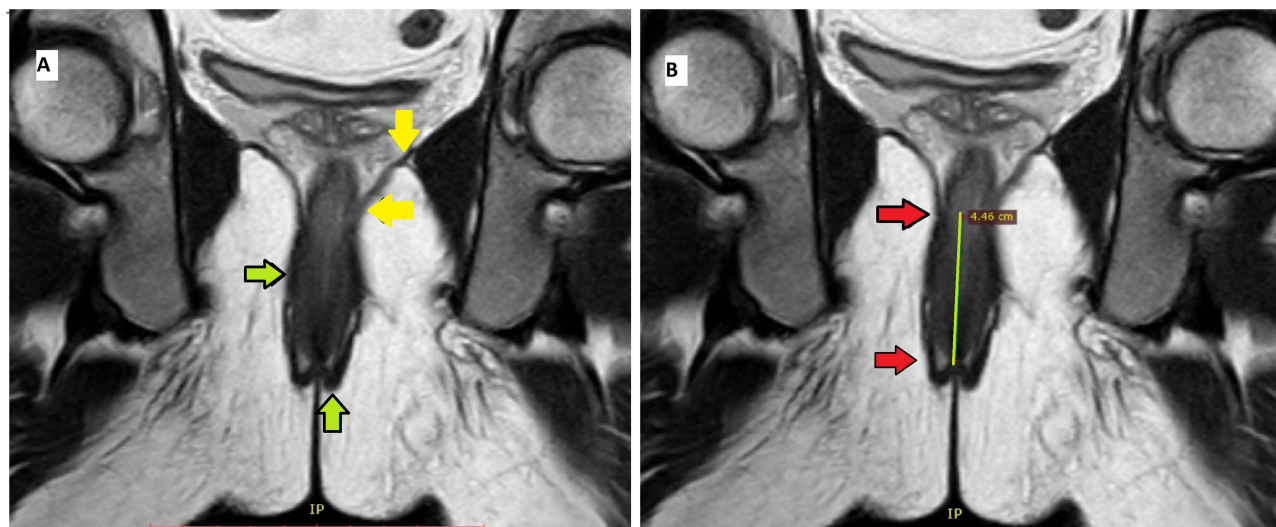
Normal anatomy- Coronal Section (MRI) and measurement of length of the surgical anal canal. Panel (A) (Left)- Green arrows showing the external anal sphincter. Vertical green arrow showing the lower border of the external anal sphincter (subcutaneous part). Horizontal green arrow showing the mid-part of the external anal sphincter (superficial part). Yellow arrows showing the levator ani muscle. The vertical yellow arrow shows the upper level of the levator ani muscle and its junction with the obturator internus muscle. The horizontal yellow arrow shows the lower border of the levator ani muscle. Panel (B) (Right)- Measuring the length of surgical anal canal. The part of the anal canal between the two red arrows [between the anorectal sling (lower border of levator ani muscle) and anal verge (where the subcutaneous part of the external anal sphincter curves inwards around the internal anal sphincter)] is the surgical anal canal. This length is measured by a vertical scale drawn on the MRI section (vertical green line). The length of the surgical anal canal is 4.46 cm in this case. The dentate line is approximately between 25–33% of this line when measured from the anal verge.
